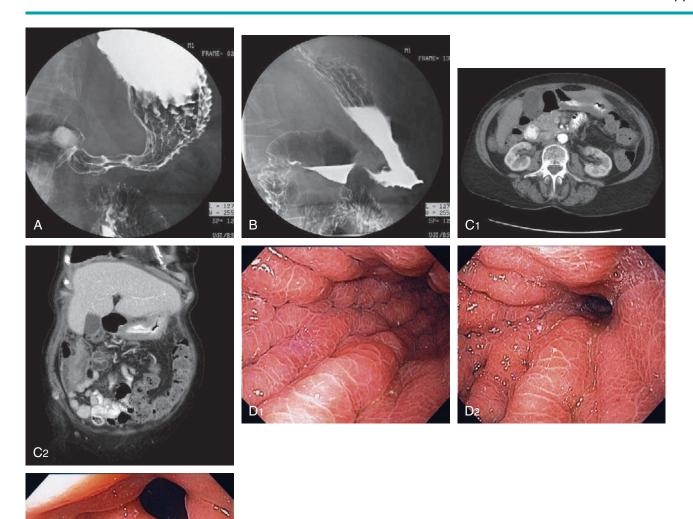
LINITIS PLASTICA SECONDARY TO METASTATIC BREAST CANCER A, B, Upper gastrointestinal (GI) series shows thickened folds with narrowing of the antrum. C1, C2, Marked thickening of the gastric wall as shown on routine and coronal CT images. D1, D2, Gastric folds are markedly thickened and the gastric lumen is narrowed. The antrum is relatively spared (D3).
